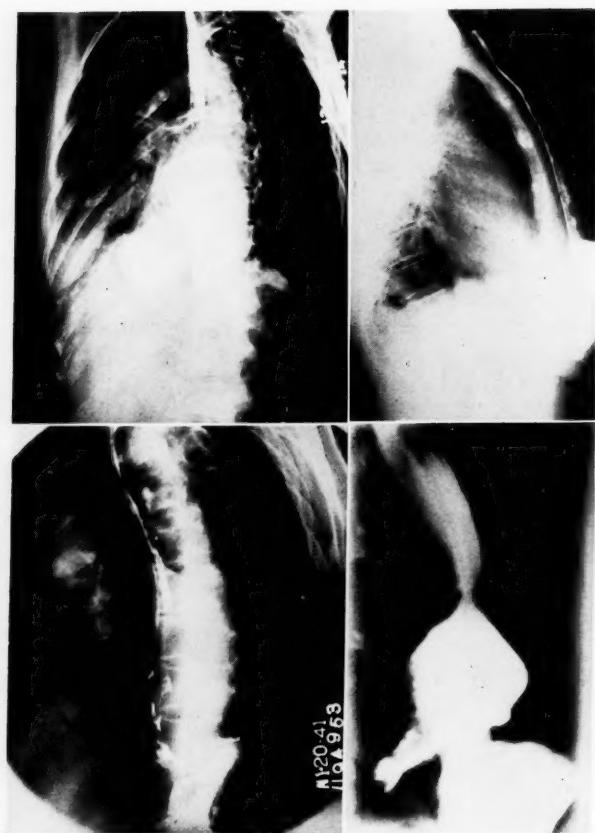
Case E. P., No. U-162314. X-ray appearance of carcinoma of thoracic esophagus later successfully resected. Patient well two and a half years after resection.
